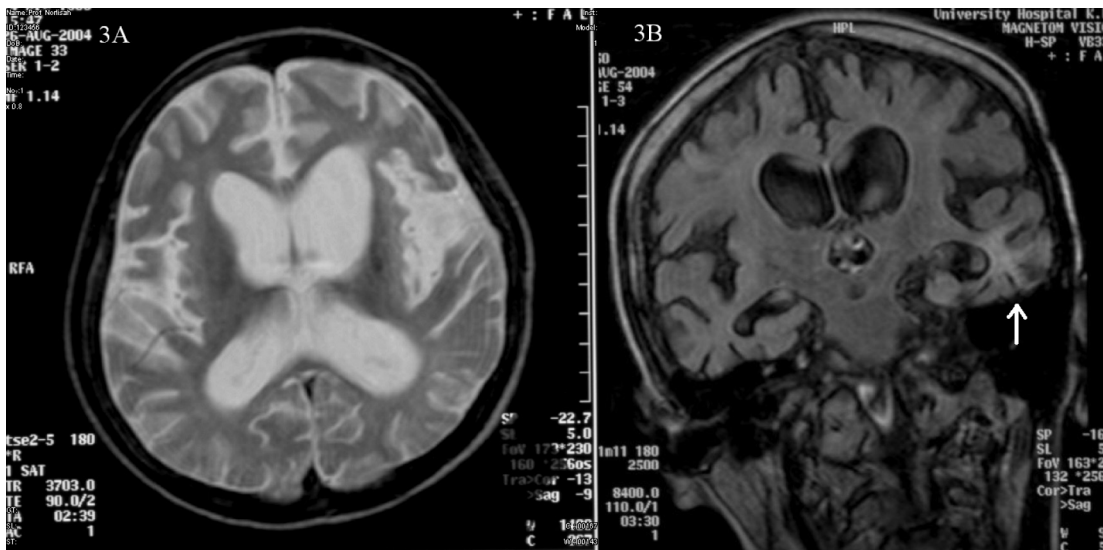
MRI T2 weighted axial and FLAIR coronal images showing generalized cerebral atrophy with encephalomalacic changes area in previously biopsied area (arrow).
